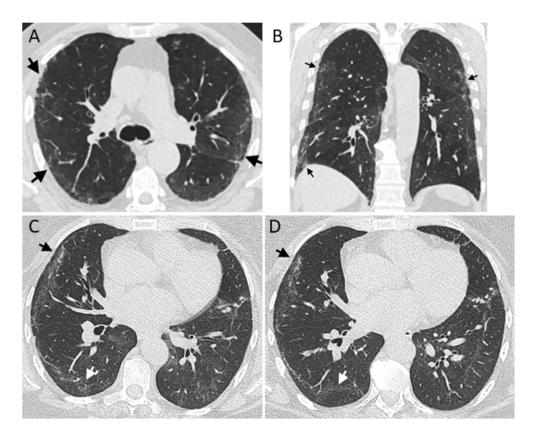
Representative CT images of residual lung abnormalities.Representative A) coronal and B) axial non-contrast CT imaging from the same individual performed at 137 days post discharge following a COVID-19 admission, scored with 52.5% total lung involvement of residual lung abnormality of which 18.3% reticulation and 34.2% ground glass opacity. Peripheral reticulation (arrows) is evident surrounded by faint areas of ground glass density. Representative coronal CT images from the same individual at C) 114 days post discharge scored with 56.8% lung involvement (28.5% reticulation; 28.3% ground glass opacity) and D) 239 days post discharge scored with 49.2% total lung involvement (20.0% reticulation; 29.2% ground glass opacity). Peripheral areas of reticulation (black arrow) and ground glass density (white arrow) in the right lung.
